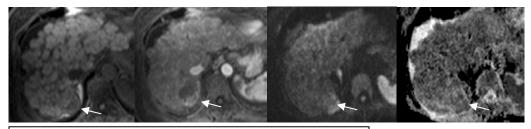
From left to right, pre-contrast fat-suppressed T1 weighted image, arterial phase of Gd-enhanced T1, DWI (b=500), and ADC map (b=0-50-500). Postcontrast T1WI demonstrates focal enhancing viable tumor (white arrow) within a chemoembolized HCC in segment 7, which was evaluated as 80% necrosis. DWI shows a bright signal intensity which indicates restricted diffusion in this area. ADC value in this area measures 1.33 x 10⁻³ mm²/sec. ADC value of the rest of tumor representing necrotic area measures 1.95 x 10⁻³ mm²/sec.
